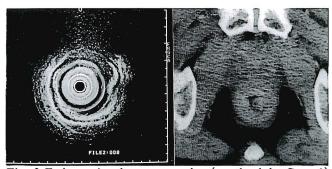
Endoscopic ultrasonography (on the left, Case 1) and a pelvic CT scan (on the right, Case 2) demonstrating a mucosal mass with the preservation of the layer structure of the rectal wall.
